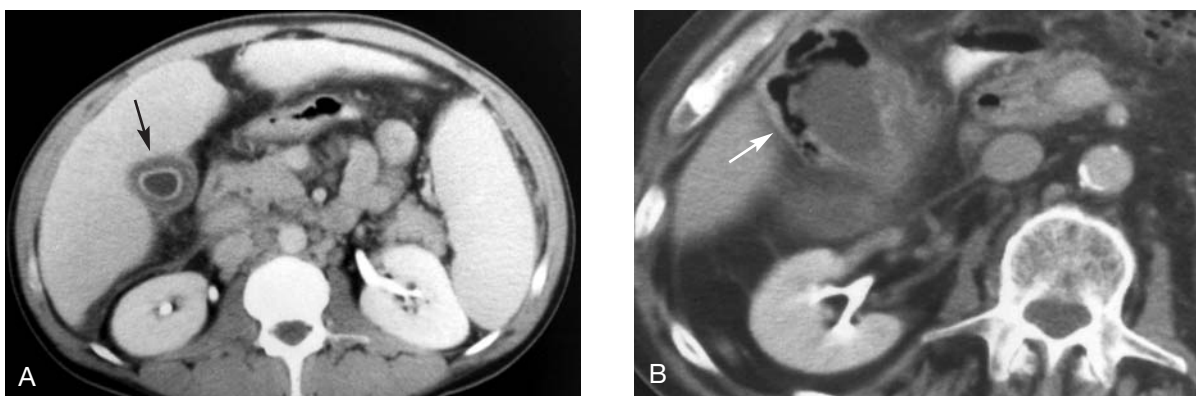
Computed tomography of complicated biliary stone disease. *A*, Thickened gallbladder wall (arrow), as seen in the ultrasonogram in Figure 7 *D*. *B*, Emphysematous cholecystitis (arrow) due to *Clostridium* species and others presents with toxicity as a medical and surgical emergency.
